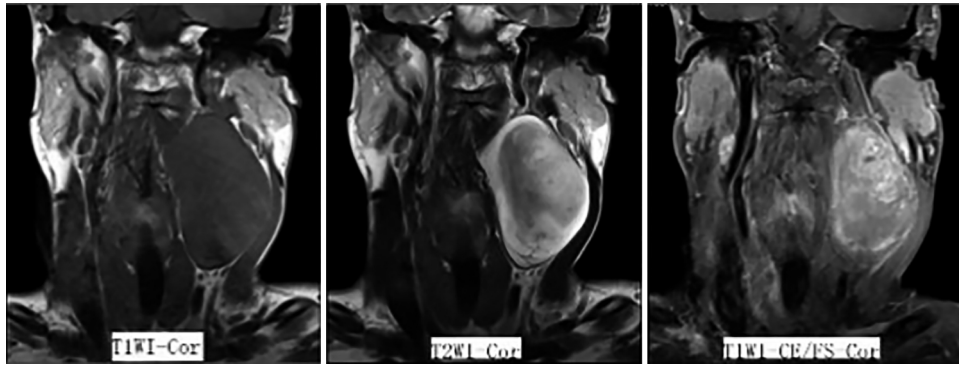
Magnetic resonance imaging (MRI). The tumor shows isointense, low signal intensity on T1-weighted MRI, both low and high signal intensities on T2-weighted MRI, and high signal intensity on Gd-enhanced T1-weighted MRI.
